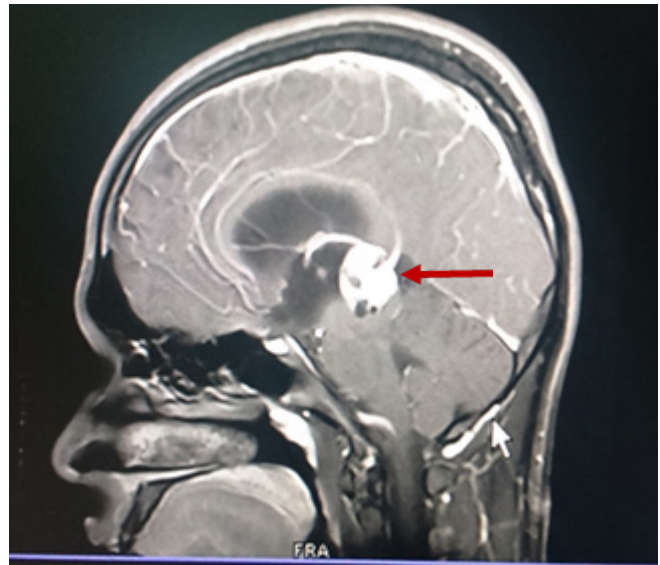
Cranial MRI with contrast
